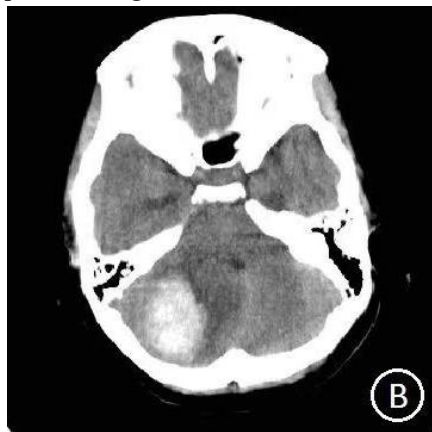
Brain Computed Tomography (CT) of patient #2
